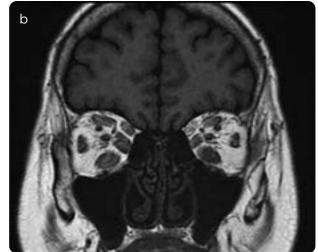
a) Coronal scan reconstruction of a patient with acromegaly: diffuse and bilateral thickening of the orbital muscles, especially the lower rectus. b) MRI, coronal with simple T1 information of a patient with acromegaly: diffuse and bilateral thickening of the extraocular muscles.
